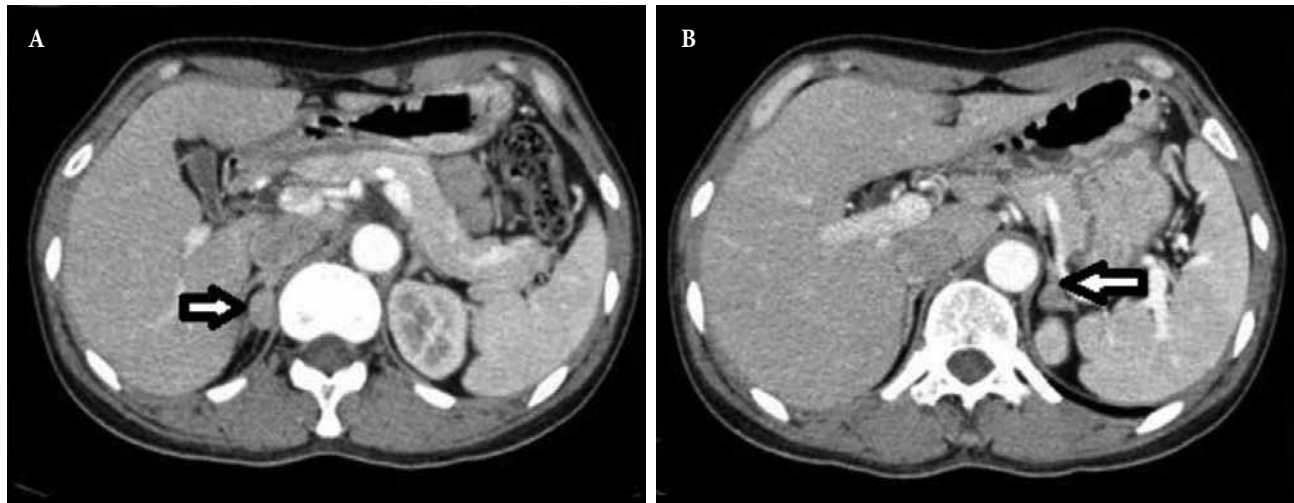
Adrenal CT with contrast medium showing bilateral adrenal tumors. (A) Right adrenal tumor measuring 2.29cm in diameter (arrow). (B) Left adrenal tumor measuring 0.92cm in diameter (arrow).
